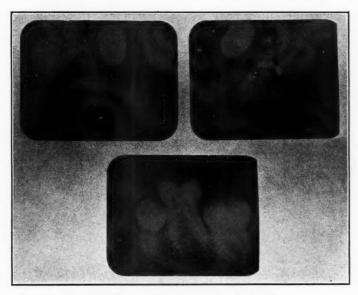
X-ray pictures showing impactions.
